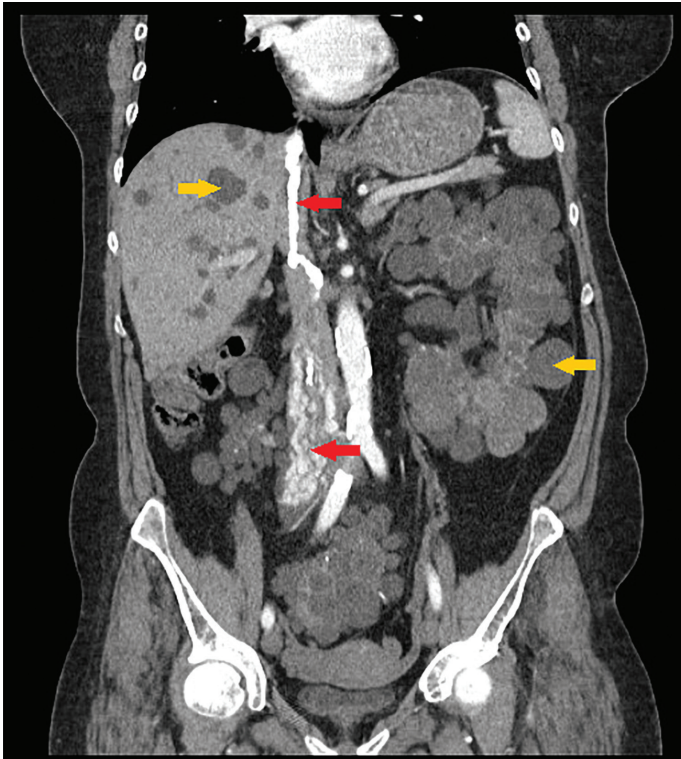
CT angiography frontal view (arterial phase): the tumor mass (red arrows) exceeded the outline of the inferior vena cava; massive linear calcifications were seen along the course of the inferior vena cava; the cystic transformation of the liver and kidneys (orange arrows) can be observed
